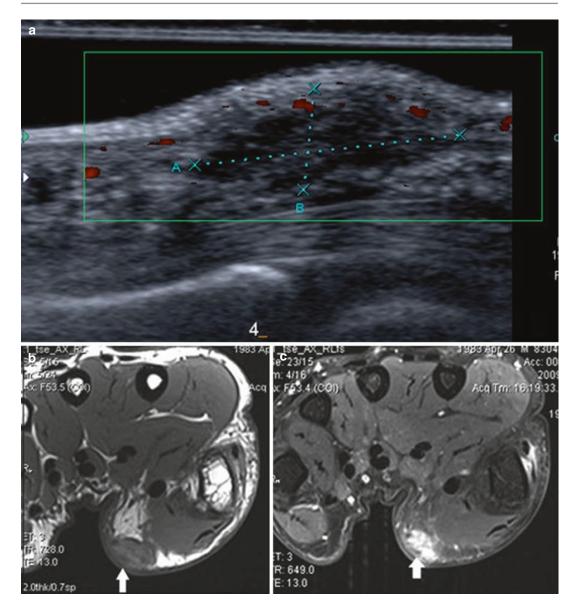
(a–c) Palmar fibromatosis. (a) Longitudinal Doppler ultrasound. Hypoechoic nodule adjacent to the flexor tendon of the palm of the hand (*third ray*). (b) Axial SE T1-WI in another patient shows a hypointense lesion at
